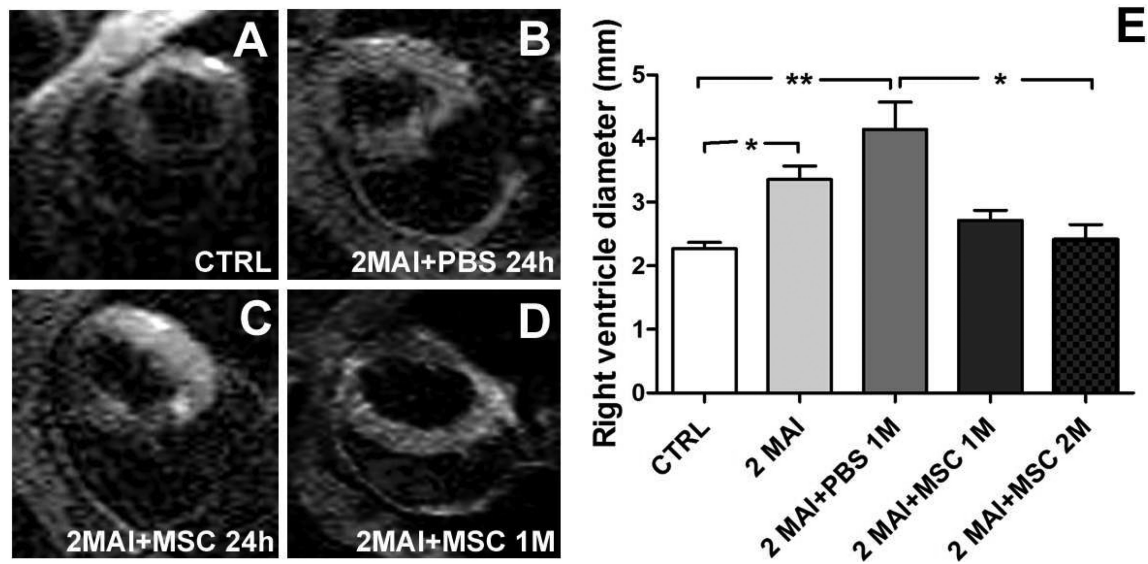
Heart morphology analyzed by MRI
